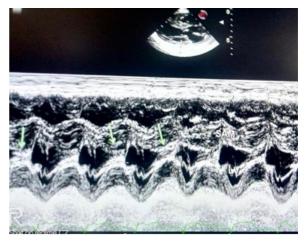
M-mode echocardiogram at the tip of the mitral valve shows that there is systolic anterior motion of mitral leaflets (SAM) towards the ventricular septum causing severe LVOT obstruction.
